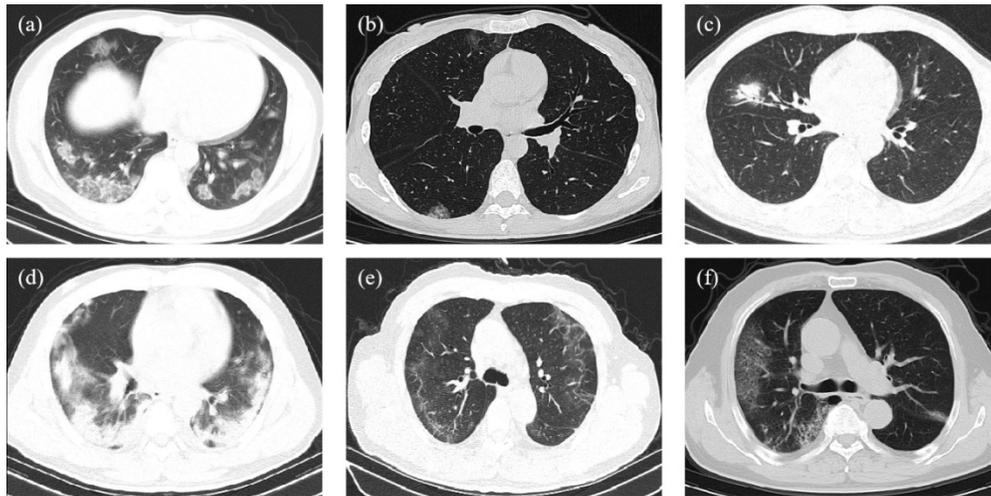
Chest CT features of COVID-19 patients. (a) Chest CT of a 48-year-old male patient. Multiple ground-glass opacities were shown in the lower lobes. (b) Chest CT after 3 days of treatment of a 34-year-old female patient. Multiple patchy GGOs were shown in the lower lobes. (c) Chest CT at admission of a 51-year-old male patient. Consolidation in the right middle lobe and air bronchogram signs were shown. (d) Chest CT after 8 days of treatment of a 36-year-old male patient. Multiple consolidations were shown in both lungs. (e) The last chest CT before discharge of a 65-year-old male patient. Subpleural lines and interlobular septal thickening were shown in the right lung, and irregular lines were present in left lung. (f) Chest CT after 3 days of treatment of a 70-year-old male patient. Multiple reticular patterns were shown in the right lung, and small consolidations were shown in the left lung.
